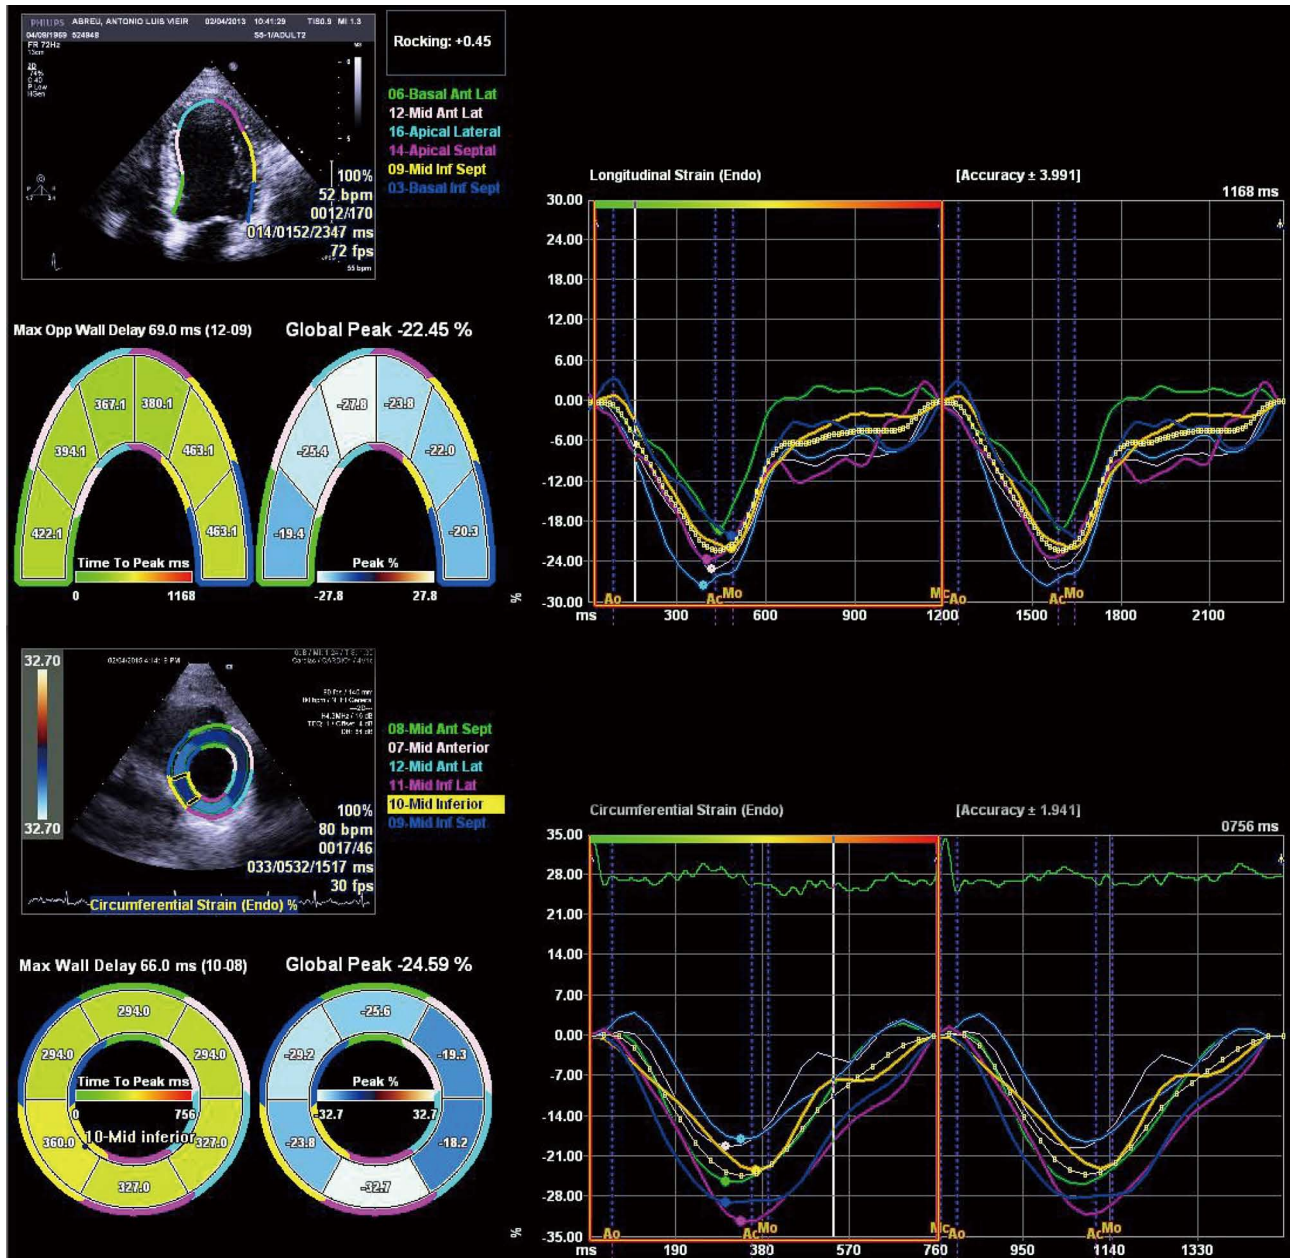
Left ventricular deformation analysis using speckle tracking echocardiography. Longitudinal (top panel) and circumferential (lower panel) strain curves are displayed.
